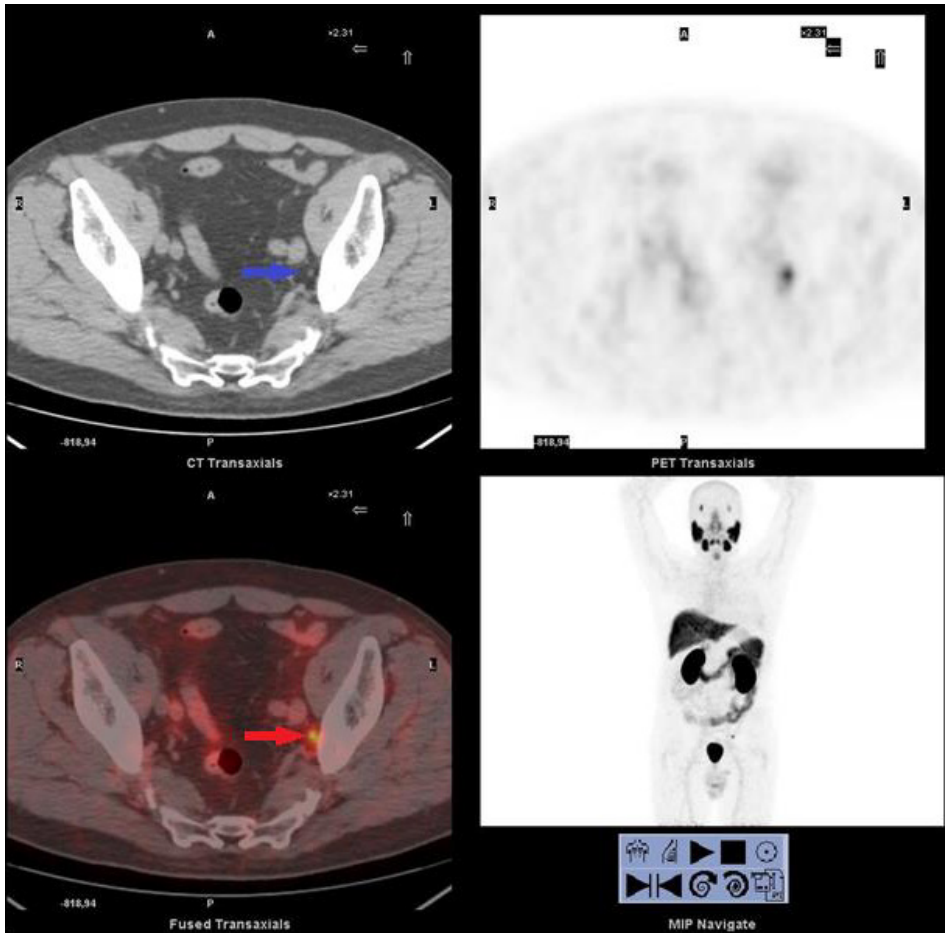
Prostate Cancer Case, (GS:7) PET-CT images of the patient. The patient undergoes Ga-68 PSMA PET-CT due to elevated PSA (PSA: 1.3 mg/dl, PSA_v: 1 ng/ml/year, PSA_{dt}: 6.1 months) after RT and HT. In PET-CT, pathological involvement is detected in 3 millimetric lymph nodes in the left obturator region. The patient is given targeted RT.
